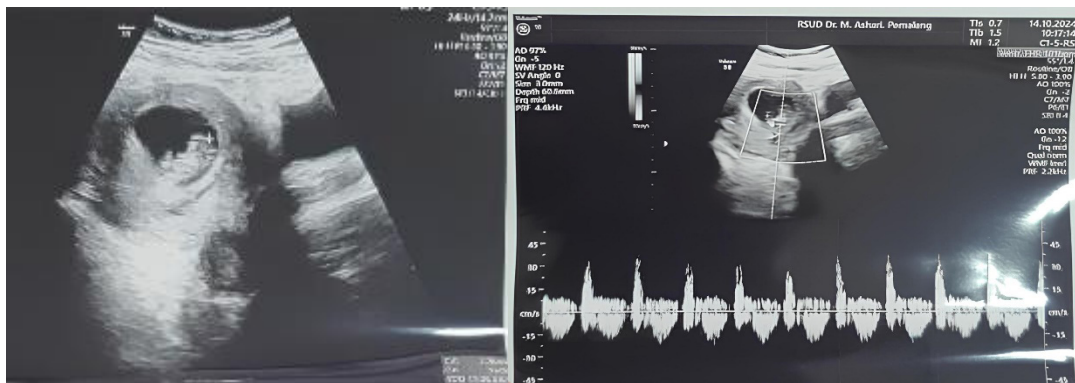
ransabdominal Ultrasonography one week after a Laparoscopic Intrauterine Device removal showing the pregnancy is progressing normally without any problems or . Tcomplications in the fetus or the gestational sac
